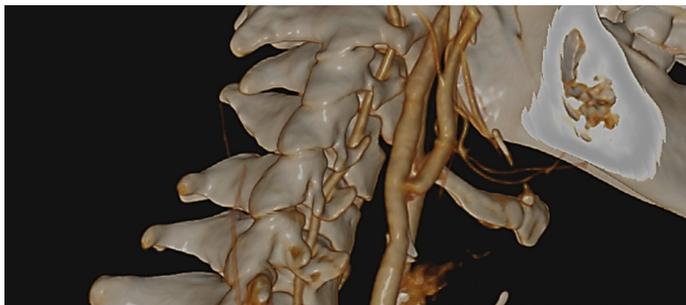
Supra-aortic CT angiography control of the PTFE graft at the third year of follow-up
